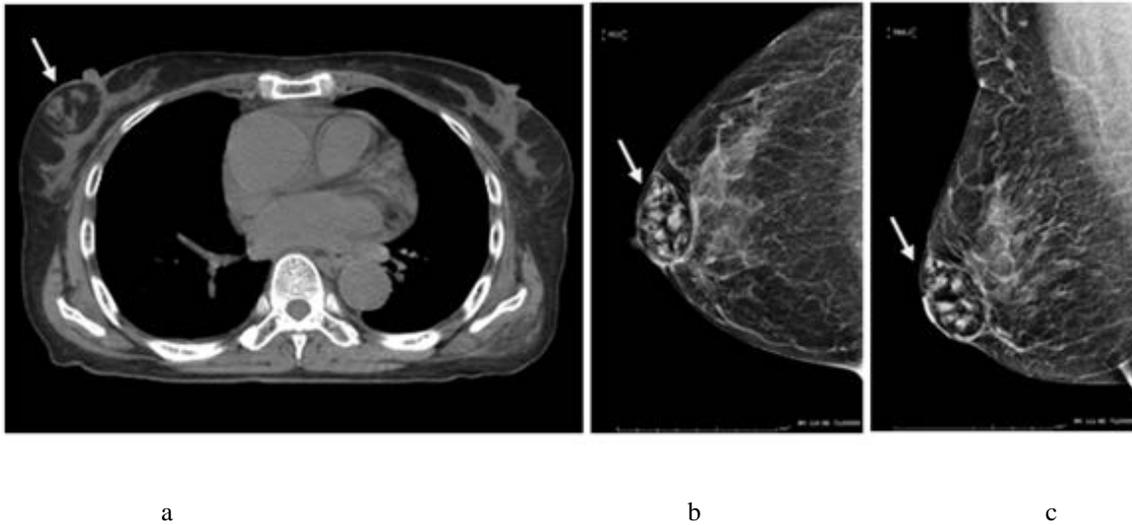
(a) Axial non-enhanced CT demonstrated right fat-containing breast mass with well-encapsulation (arrow), likely breast hamartoma and classified as BI-RADS 2.
